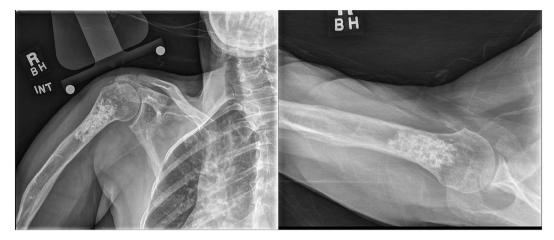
Anteroposterior and lateral radiographs demonstrating a superior-riding humeral head with a proximal humerus enchondroma.
